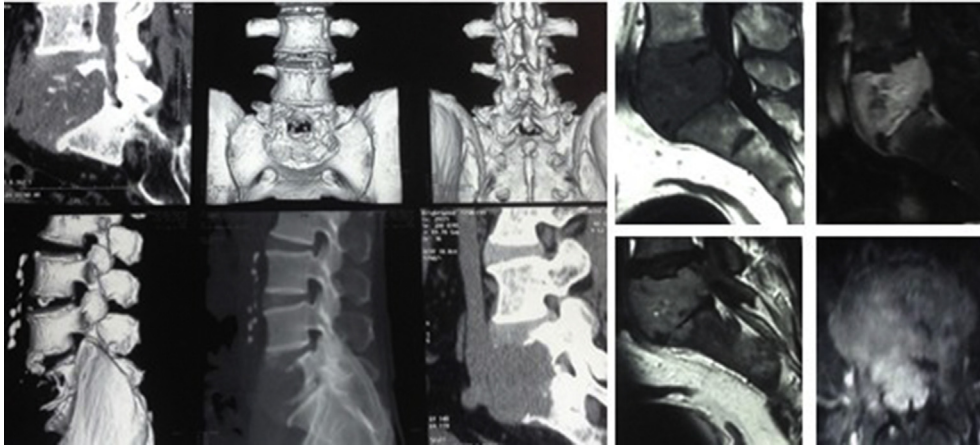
Lumbar CT and Magnetic resonance imaging demonstrated a solitary intramedullary osteolytic lesion at L5 level.
